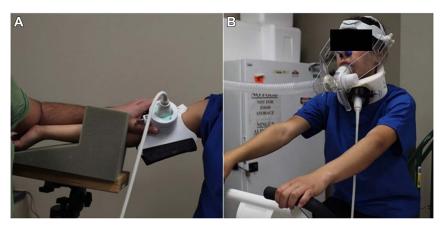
Ultrasound imaging during exercise on the brachial artery (A) and carotid artery (B) using a patent pending probe holder.
